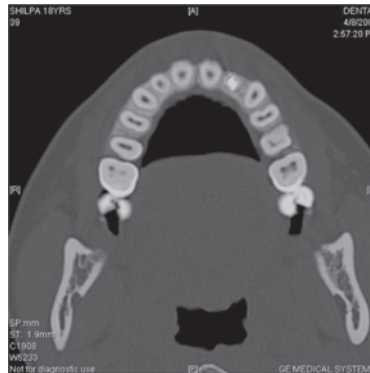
Computed tomographic (CT) view of the maxilla.
